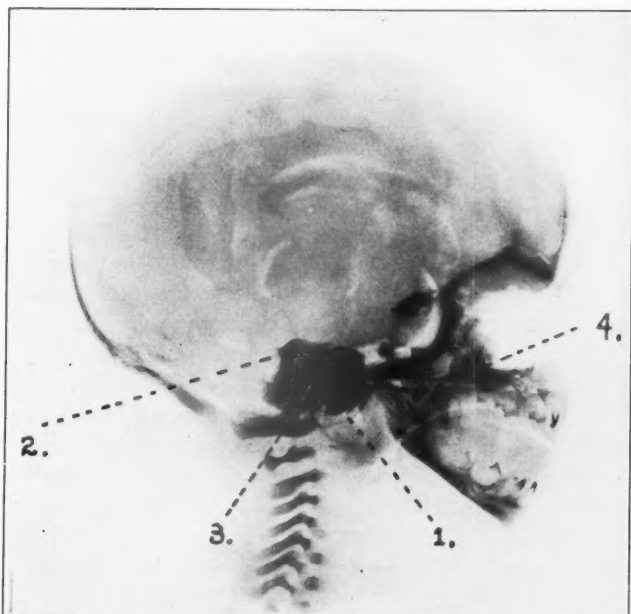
Roentgenogram of a vertically sectioned infant head. 1. The annulus can be seen in its oblique position. 2. Two of the semicircular canals are plainly shown. 3. Lipiodol fills the middle ear and mastoid antrum, the latter appears to be almost directly above the former. 4. Lipiodol has been injected into the middle ear and mastoid through the eustachian tube.
